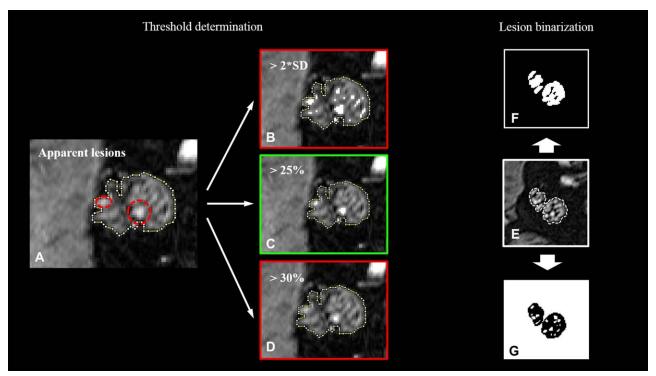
Lesion threshold and binarization of lesions. (A) Visible T2-weighted (T2w)-hyperintense lesions (encircled with dashed line) in a participant without diabetic neuropathy. (B) The automated segmentation of nerve lesions at a threshold of 2 standard deviations (SD) above the average muscle signal also identifies part of the vital nerve tissue as lesions. (C) Lesion segmentation at a threshold>25% of the average muscle signal; lesions and vital tissue are differentiated correctly. (D) Insufficient detection of lesions at a threshold>30% of the average muscle signal. (E) Sciatic nerve in a participant suffering from diabetic neuropathy. (F) Binarized map of T2w-hypointense lesions identified via thresholding. (F, G) Binarized maps of T2w-hypointense and T2w-hyperintense lesions, respectively, identified via thresholding. [Color figure can be viewed at www.annalsofneurology.org]
